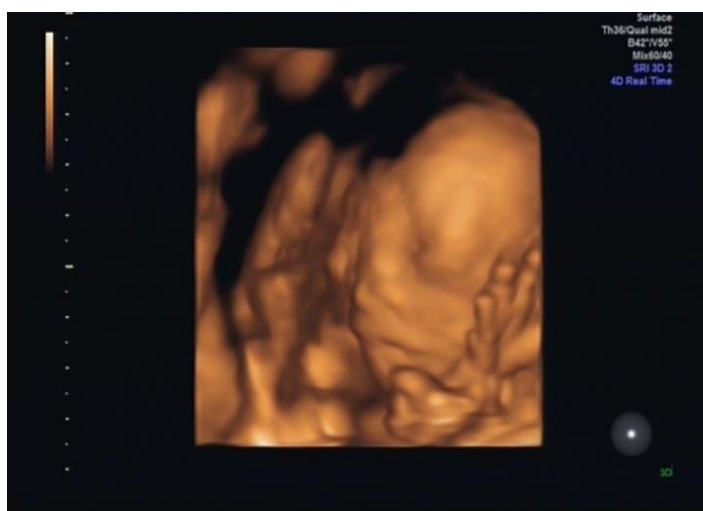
4D Real Time ultrasound examination: Fetal craniofacial morphology at 19th week of pregnancy: Bilobed nasal pyramid.
